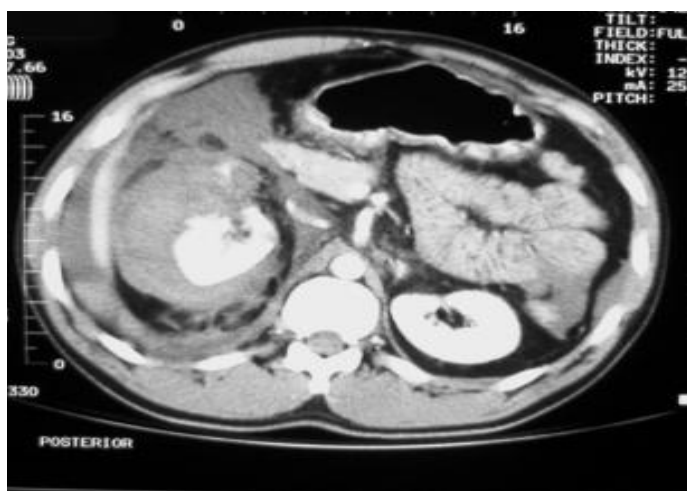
Blunt abdominal trauma. CT shows right kidney injury with blood in perirenal space. The injury resulted from a high-speed motor vehicle collision.
